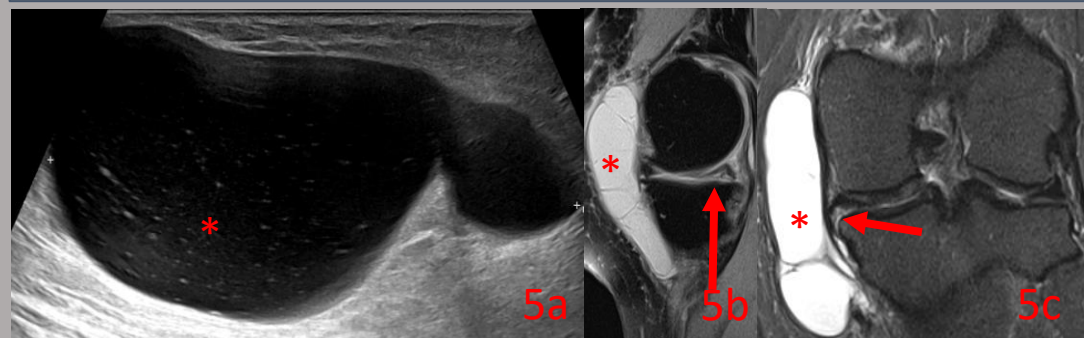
(above) - Longitudinal US (a) of a large peri-articular cyst (*). Subsequent MRI (sagittal PDFS (b) and STIR coronal (c)) show the cyst as high signal (white) fluid. The MRI also shows a tear (arrows) extending to the undersurface of the adjacent meniscus. As such, the likely diagnosis is parameniscal cyst. If no meniscal tear is present on MRI, parameniscal cyst is unlikely. The differential includes pes anserine bursa (see description of bursae in case 4) and ganglion cyst from the knee joint or pes anserine tendons.
